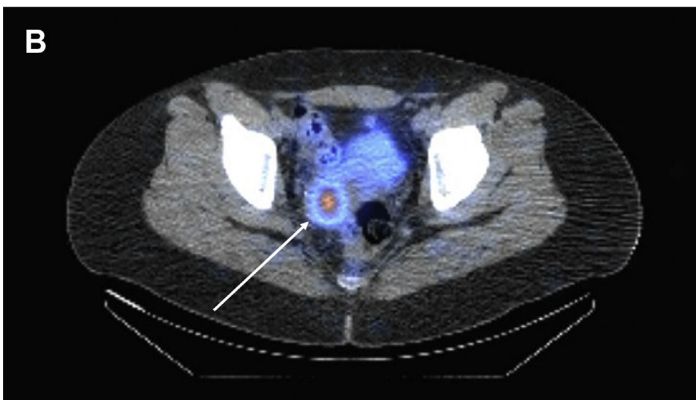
A 27-year-old woman with thyroid cancer status post thyroidectomy. (A) I-123 total body scan shows remnant thyroid activity and unexpected focal activity in the right pelvis (arrow). (B) On SPECT/CT scanning, this activity localized to the right uterus (arrow). Given a normal follow-up pelvic ultrasound examination, this result was favored to represent physiologic uterine activity.
